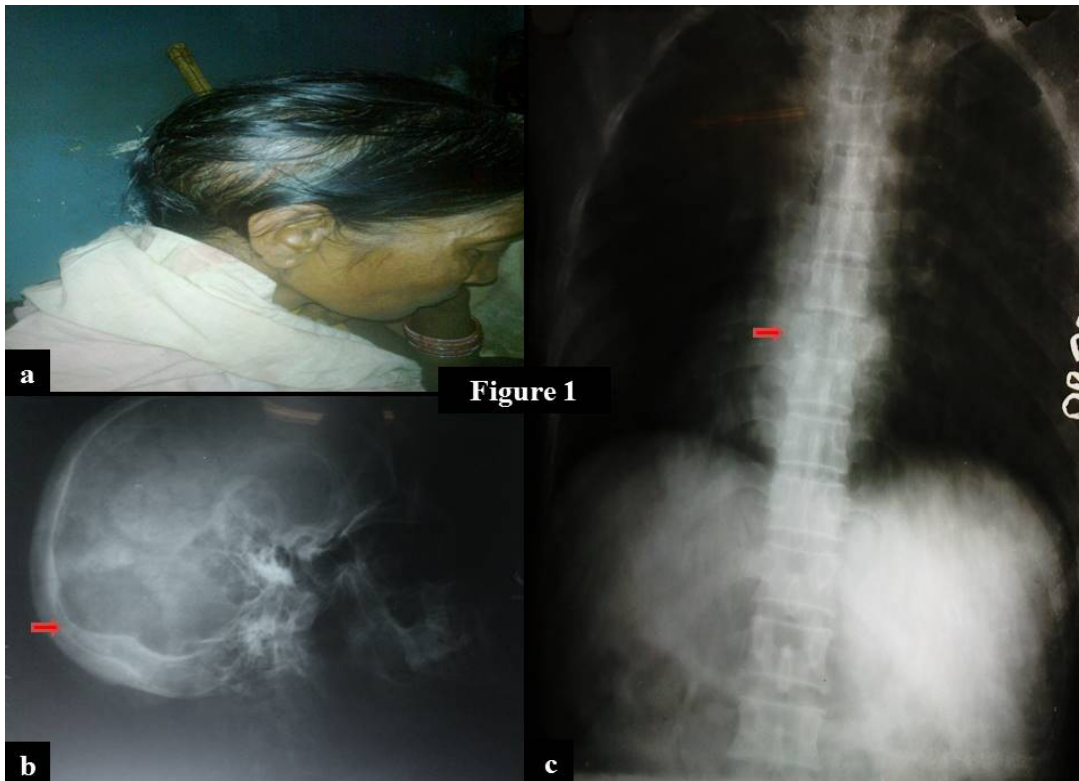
a,b,c: 58-year-old female with swelling over the occipital area. X-ray of the skull showing irregular osteolytic lesion in the right occipital area with separation of diploic space and enlarged feeding vessels. X-ray spine shows collapsing D8 vertebrae.
